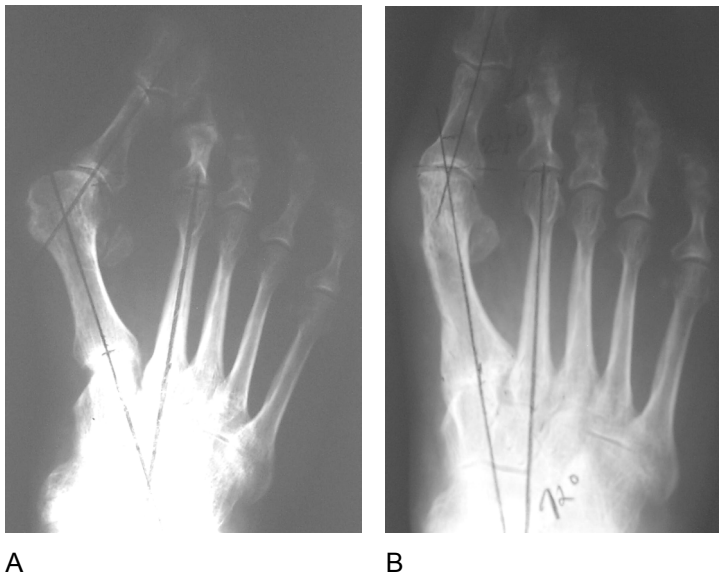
First tarsometatarsal joint arthrodesis. Preoperative (A) and one year postoperative (B) radiographs.
